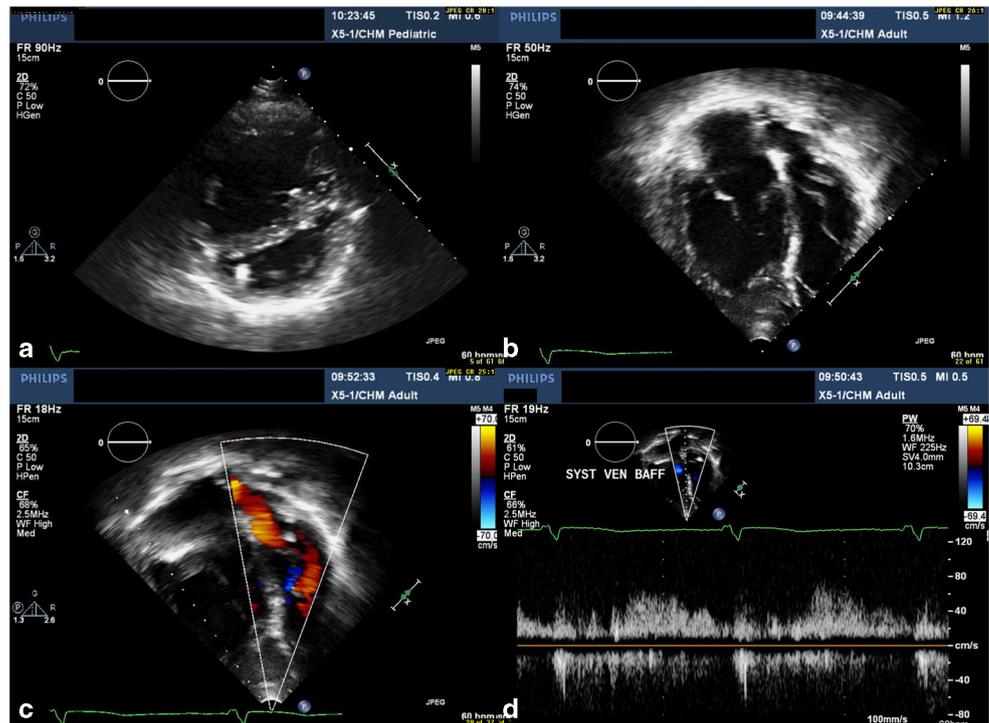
A 30-year-old male with D-TGA post atrial switch operation. (a) Parasternal short axis view showing dilated, hypertrophied systemic RV resulting in bowing of the intraventricular septum into the LV. (b) Apical 4 chamber view showing the systemic venous baffle (SVB) in the left atrium and a dilated, hypertrophied RV. (c) Apical 4 chamber view showing flow across the SVB. (d) Continuous wave Doppler across the SVB showing low velocity, phasic flow suggesting no stenosis
